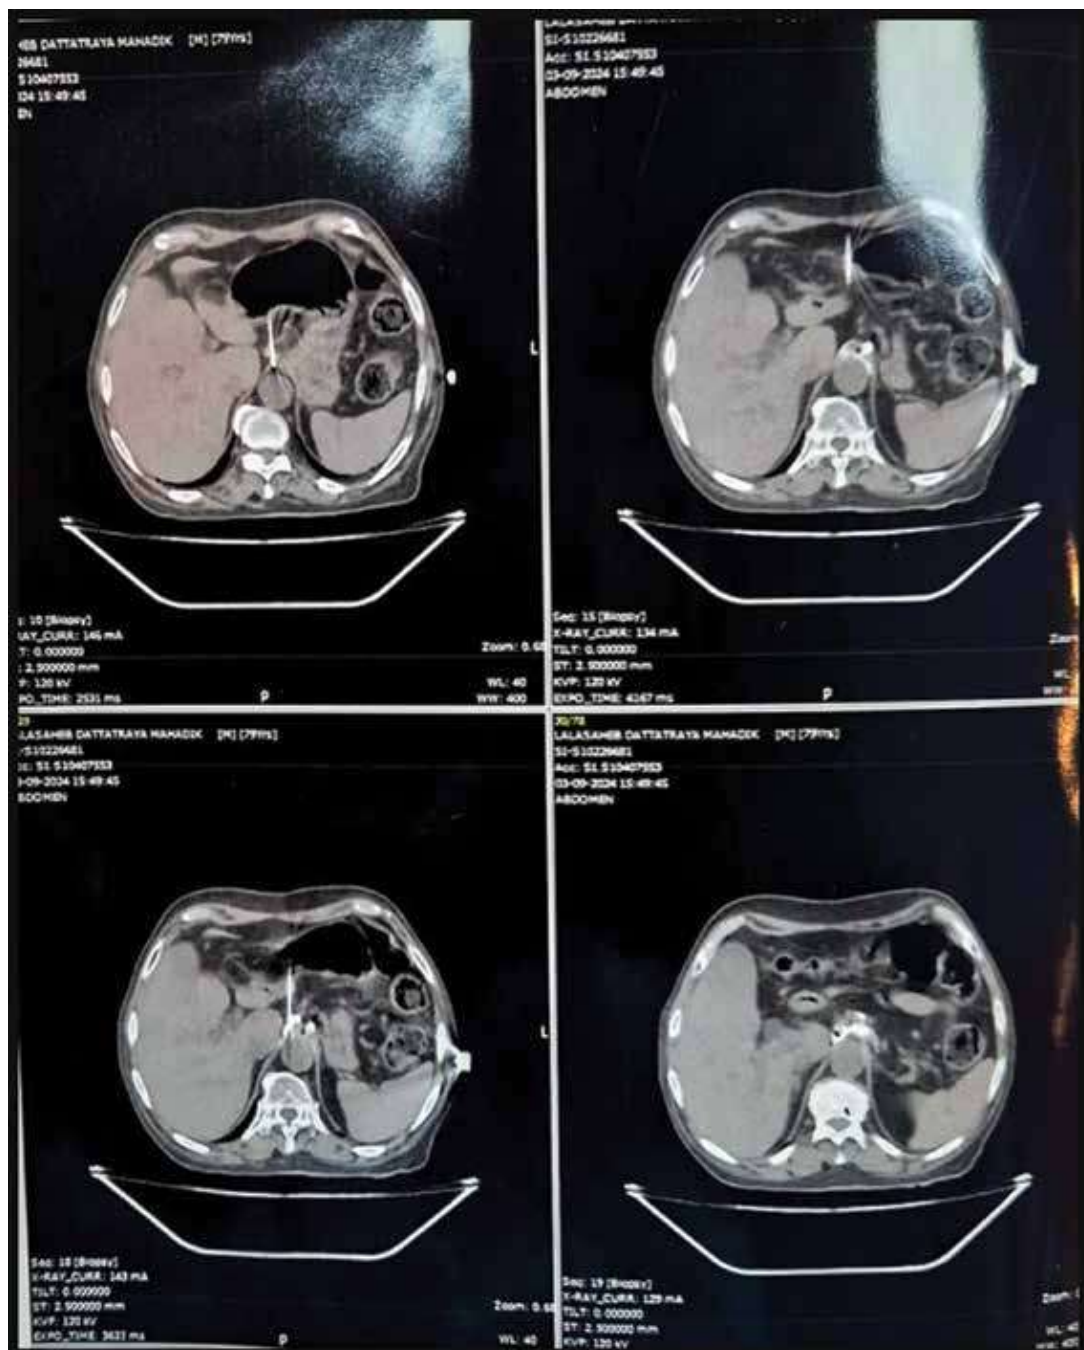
Single needle technique: CT scan shows tip of needle is placed anterior to the aorta between the celiac axis and superior mesenteric artery and spread of the contrast material around the aorta.
